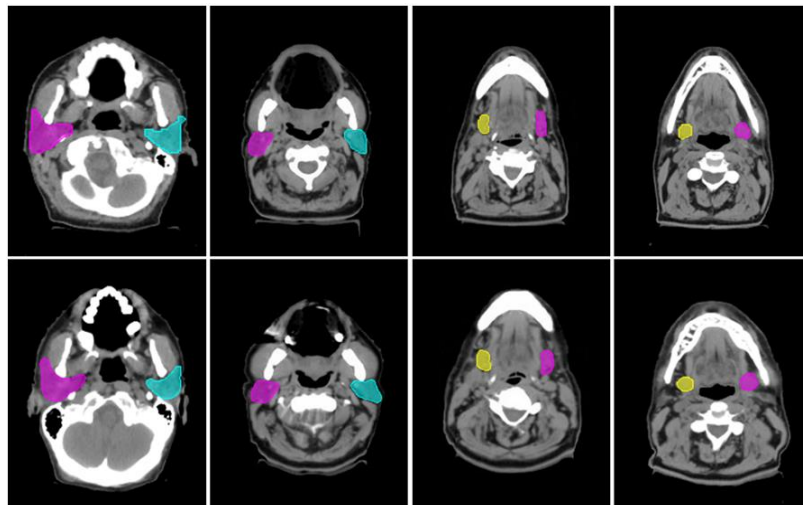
Comparisons between original and synthetic CT scans with contours. The top row are the original CT scans, and the bottom row are the corresponding synthetic CT scans.
